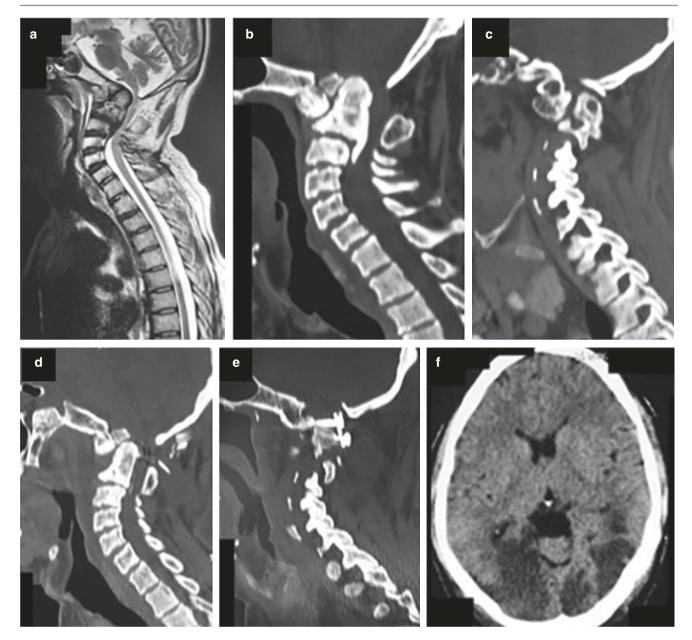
Imaging findings in a 55-year-old man. Preoperative T2-weighted magnetic resonance imaging shows basilar invagination and spinal cord compression (a). Computed tomography (CT) demonstrates basilar invagination, assimilation of the atlas, and an ossified posterior longitudinal ligament in the region of the C2 and C3 vertebral bodies (b), along with a high-riding vertebral artery (c; sagittal cut
